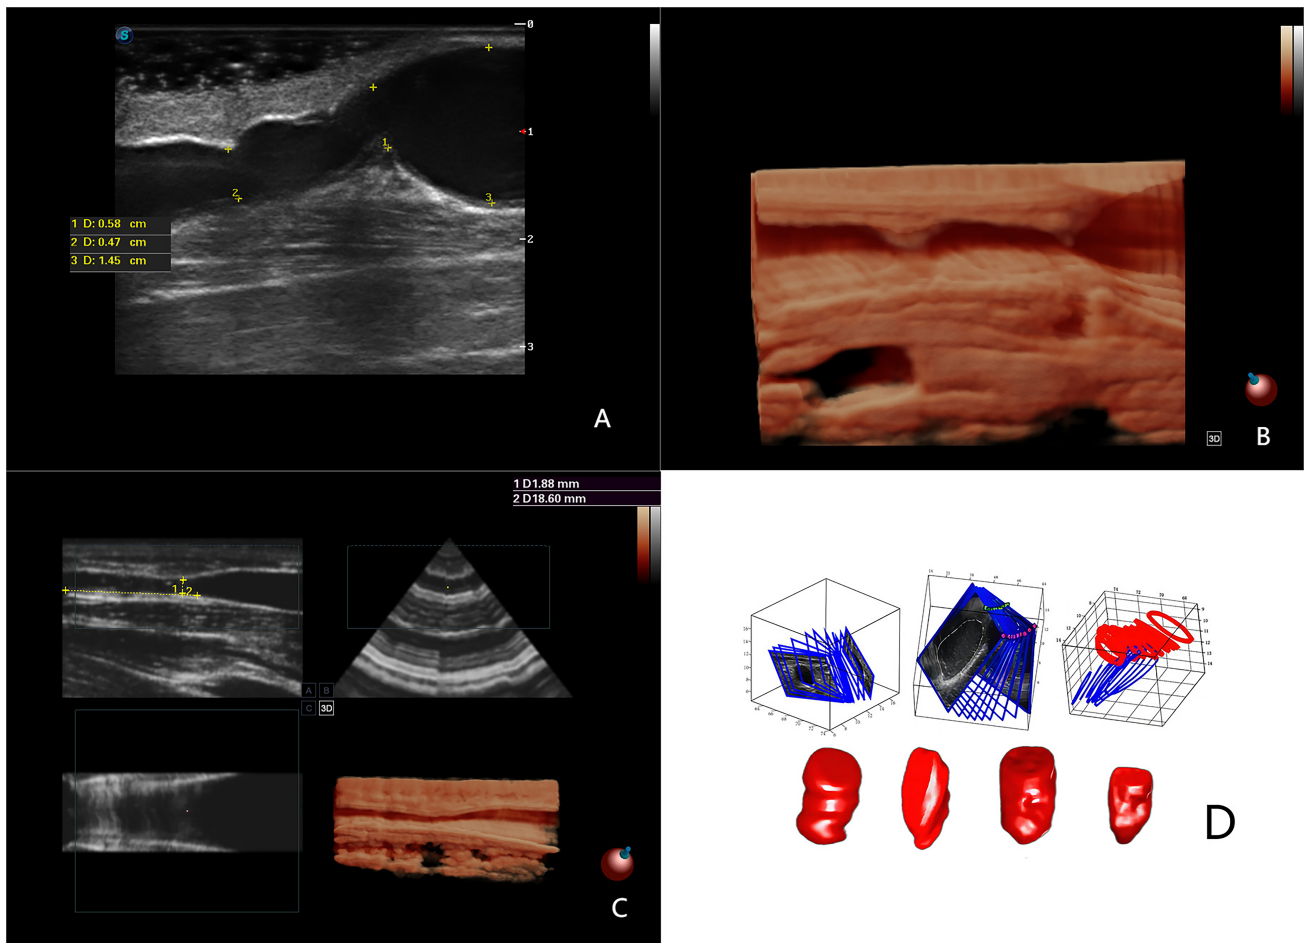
Principles of freehand 3D ultrasound imaging. (A) The stenosis of the fistula is displayed by conventional ultrasound. (B) To return the stenosis lesions through freehand 3D ultrasound reconstruction. (C) Freehand 3D imaging Reconstruction Based on 2D Images. (D) Principles of freehand 3D ultrasound imaging. 2D, 2-dimensional.
